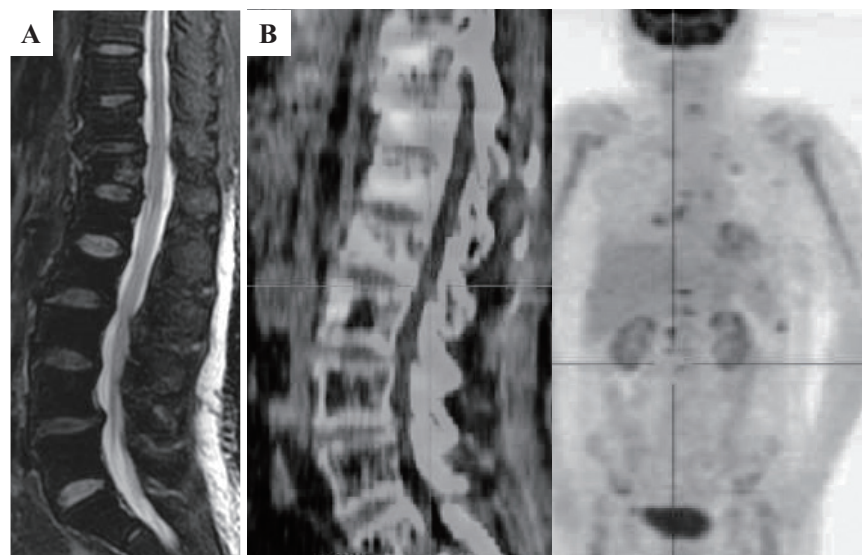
MRI and FDG-PET scan images after intrathecal chemotherapy. A: Four months after the intrathecal chemotherapy, sagittal T2-weighted images (fat suppression) showed that the intradural enhanced lesion had almost disappeared. B: Nine months after the intrathecal chemotherapy, FDG-PET showed lesions throughout her body, with the exception of the intradural lesion (Fig. 4B). MRI, magnetic resonance imaging. FDG-PET, fluorodeoxyglucose-positron emission tomography.
